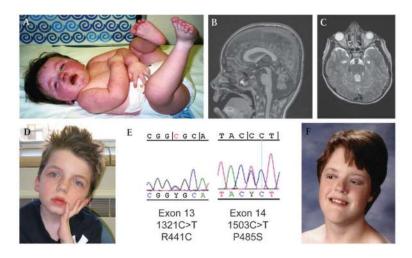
Facial features, brain imaging and mutations for UW65 and UW49. (A) UW65 at 11 months of age. (B and C) Sagittal T1 weighted and axial T2 weighted brain magnetic resonance images demonstrating the molar tooth sign. (D) UW65 at 9 years of age. (E) *MKS3* sequence tracings for UW65. (F) UW49 at 20 years of age. Photographs printed with permission from the families.
